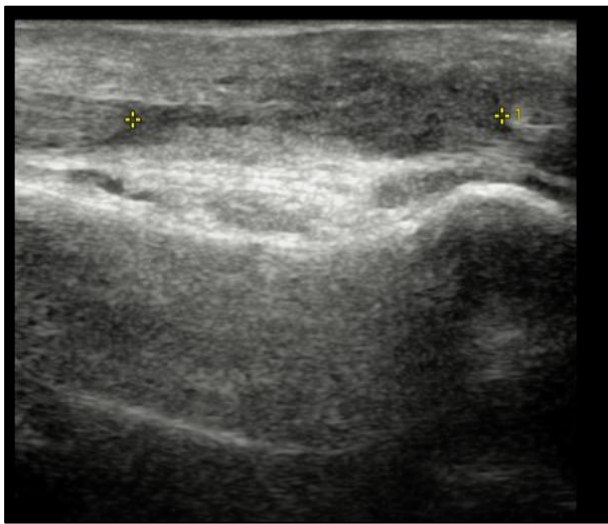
Ultrasound of extensor hallucis longus tear is seen more proximal, at the level of the midfoot, with torn and frayed ends retracted up to 2.2 cm.
